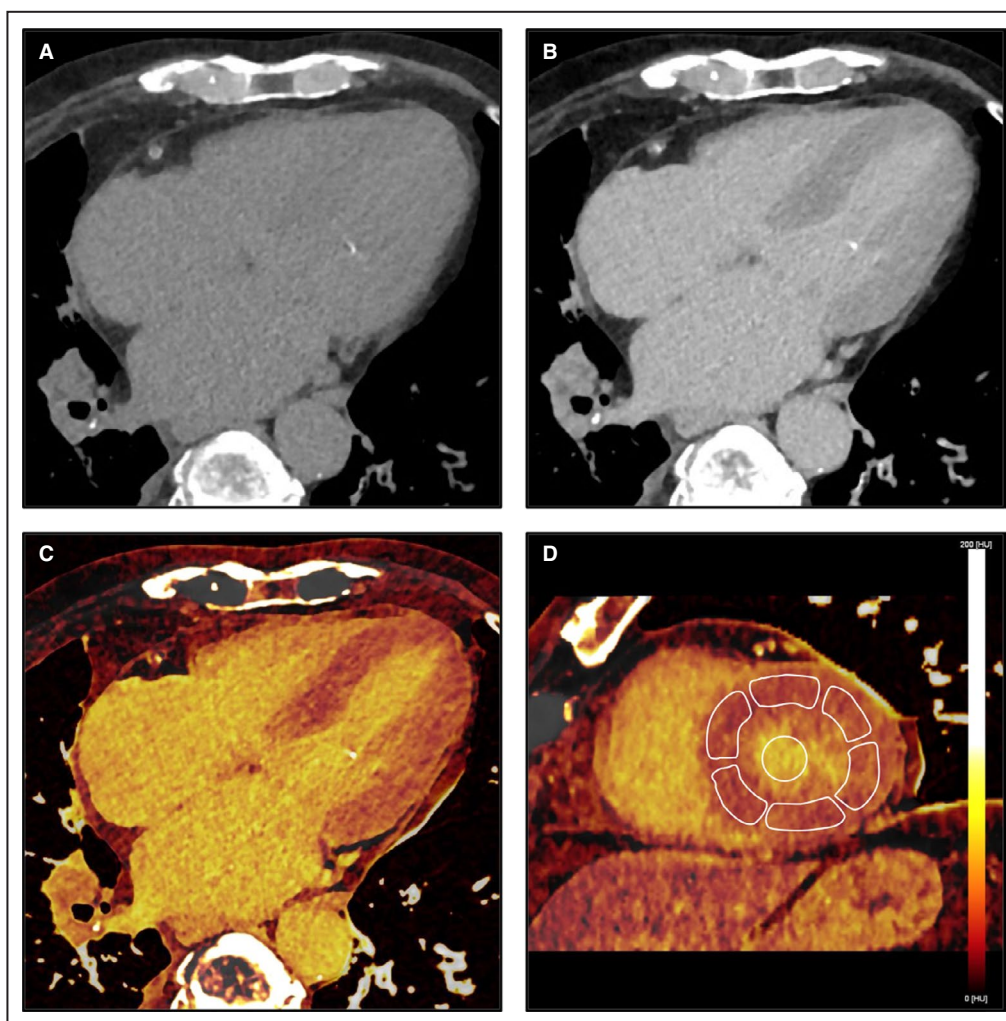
Methods for measuring extracellular volume fraction with dual-energy computed tomography.
